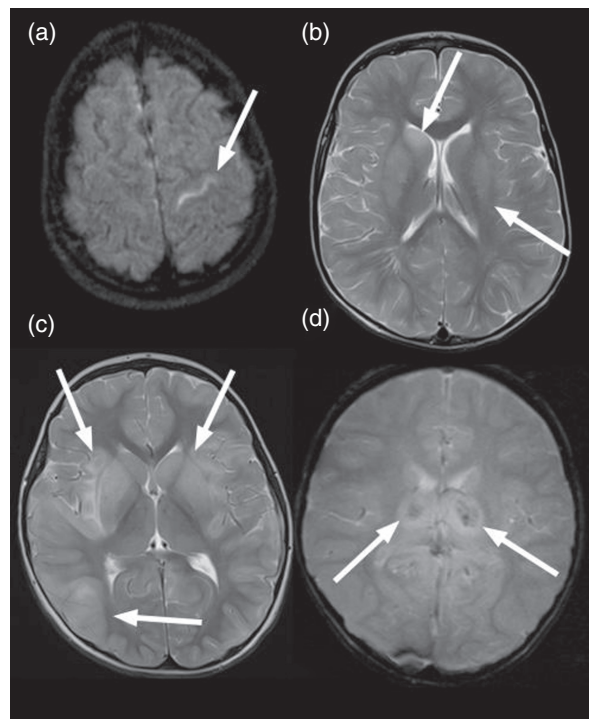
Examples of the abnormal brain magnetic resonance imaging findings in different severity categories: (a) meningeal enhancement (category 2), (b) multiple focal brain lesions (category 3), (c) confluent brain lesions (category 4), (d) hemorrhagic brain lesions (category 5).
